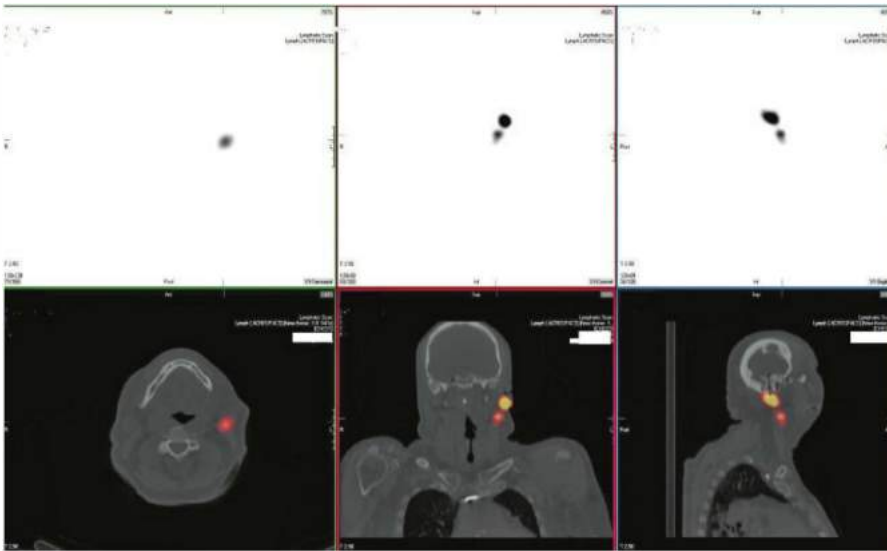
• Lymphoscintigraphy with SPECT-CT imaging after injection of left postauricular primary melanoma site. Careful observation reveals the level II lymph node to be located just inferior to the tail of the parotid and just anterior to the sternocleidomastoid muscle. Likely, this represents an external jugular lymph node.
